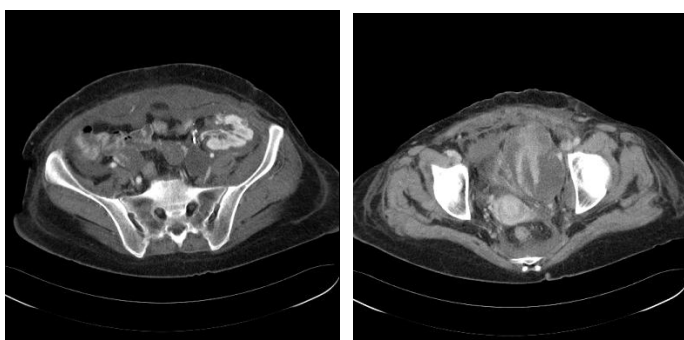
A-B: Abdominal CT showed contrast-enhanced extravasation compatible with active hemorrhage and hematoma extending from the posteriomedial transplant kidney to the pelvis (Figure 4 A-B).
